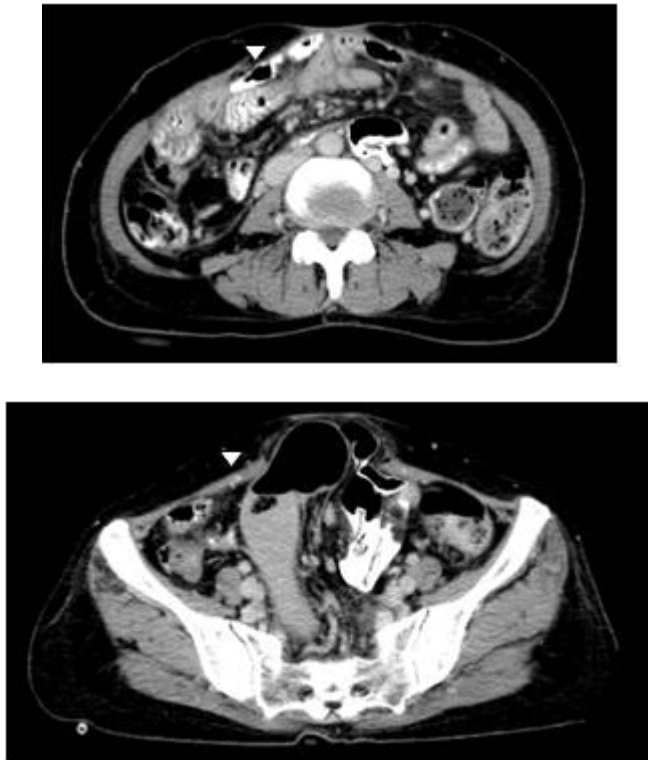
CT scan indicates an incisional hernia (arrow heads) containing the bowel.
